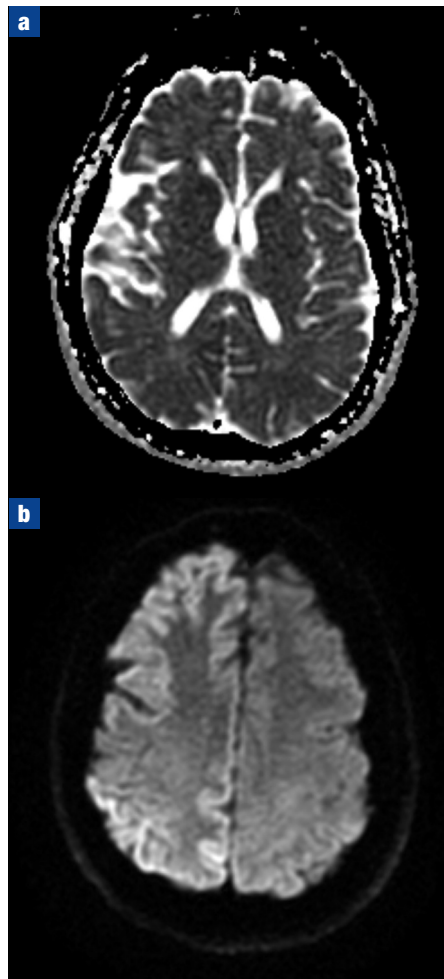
Magnetic resonance image of his brain showed restricted diffusion of the cortex in the frontal, parietal and occipital lobes on the right.
